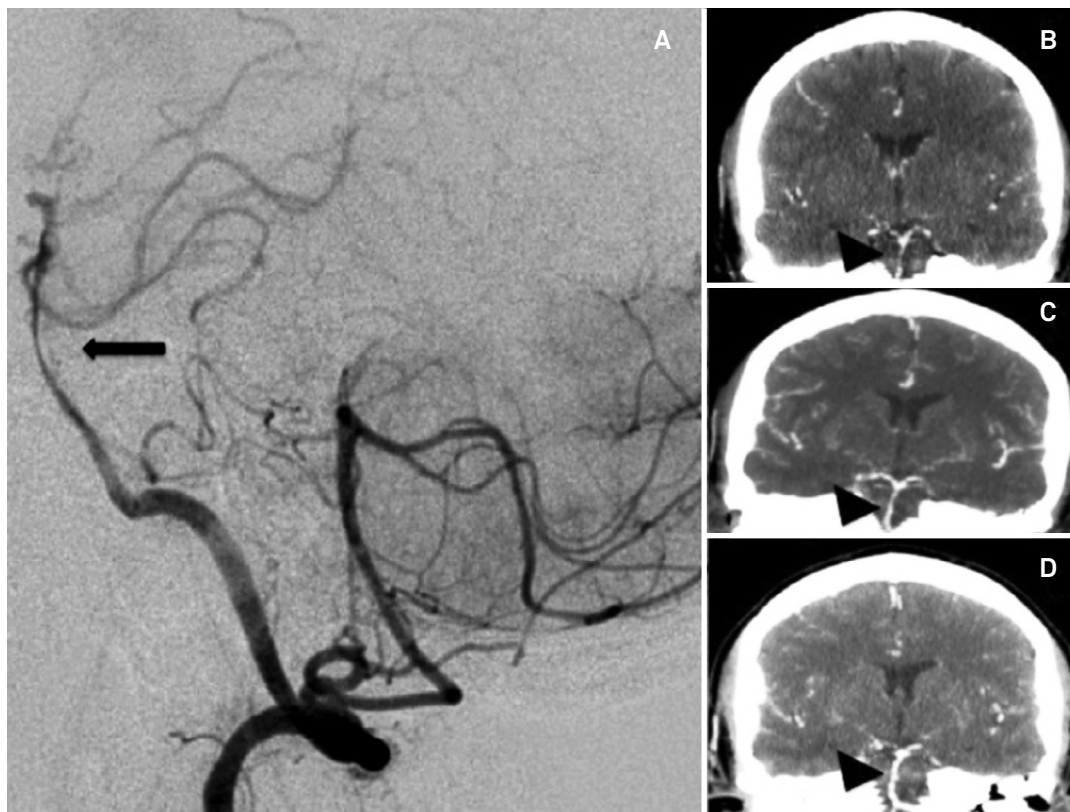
A) Basilar artery dissection without vertebral artery involvement in Digital Subtraction Angiography – lateral image (arrow). B) CT-angio: Isolated narrowing of basilar artery in day 1 (arrowhead). C) Partial recanalization of basilar artery lumen in day 7 (arrowhead). D) After six months, basilar artery without pseudoaneurysm and improvement of recanalization (arrowhead).
